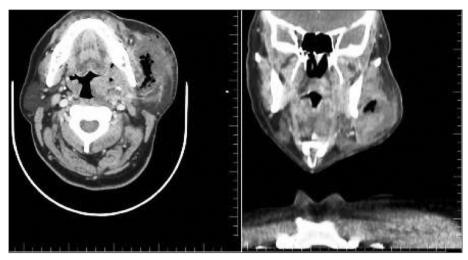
The patients' neck computed tomography images.
